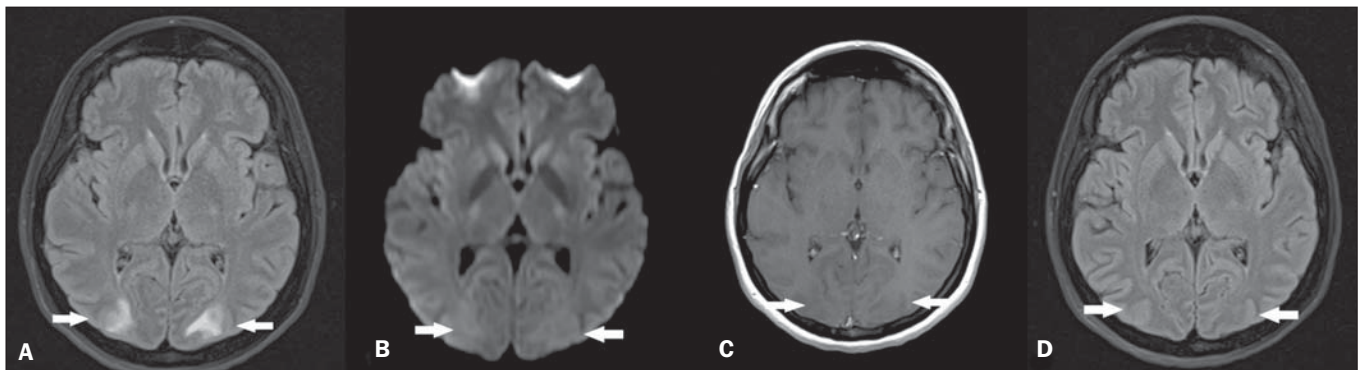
A: Axial MRI FLAIR sequence demonstrating hyperintensity in the occipital lobes white substance bilaterally and symmetrically (arrows). B: Axial diffusion-weighted MRI does not demonstrate any alterations (arrows). C: Contrast-enhanced T1-weighted sequence revealing absence of gadolinium-enhanced areas (arrows). D: Axial FLAIR sequence acquired after four weeks demonstrating resolution of the alterations in the occipital lobes white substance (arrows).
